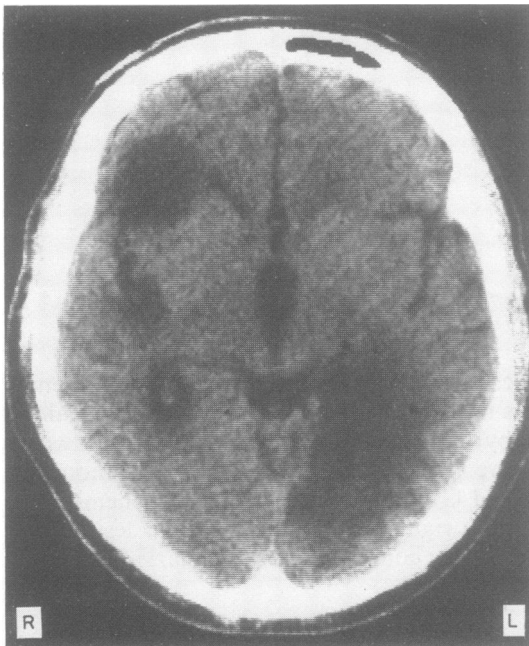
Head CT scan at 9 months after stroke shows lesions in the left posterior temporal region and left occipital region infringing on the posterior corpus callosum. The effect of the various infarctions in the left hemisphere was to create one relatively large lesion. In addition, a right hemisphere opercular lesion is seen.
